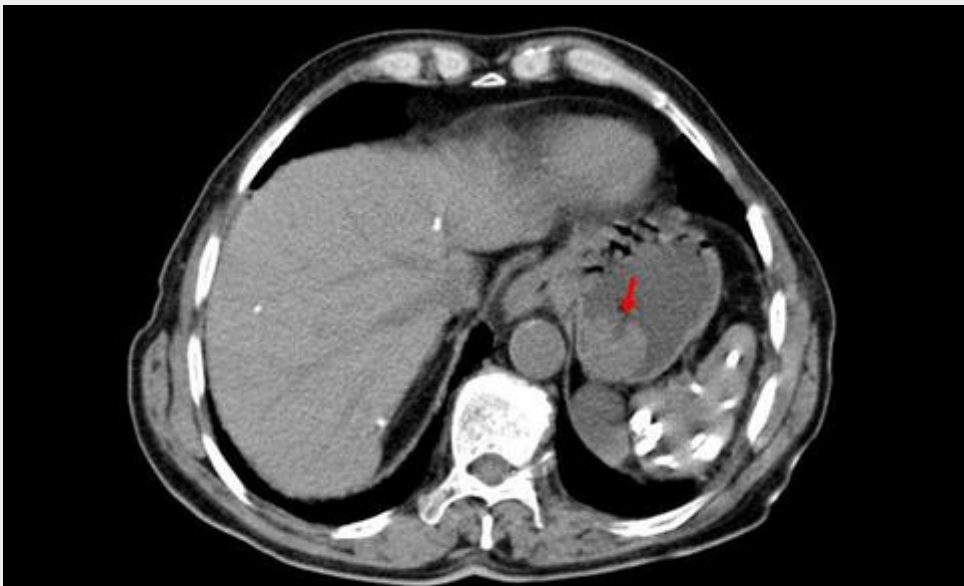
GIST. Pre-contrast CT images shows round, endophytic, soft tissue density mass in the posterior wall of the gastric body (→). Multiple gross liver and spleen calcifications were incidentally found.
